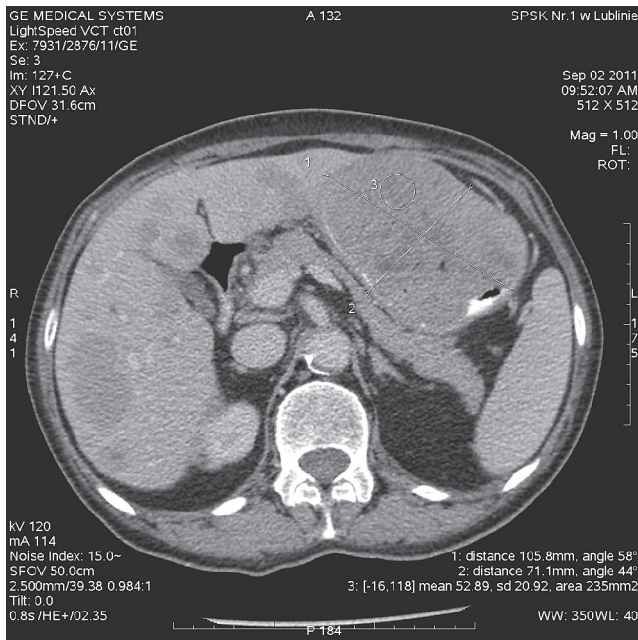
Axial CT image before contrast administration shows a massive soft tissue tumour of the upper part of the stomach. The lesion measures 103 x 67 mm and compresses the left lobe of the liver. Note also the inhomogeneity of the liver
